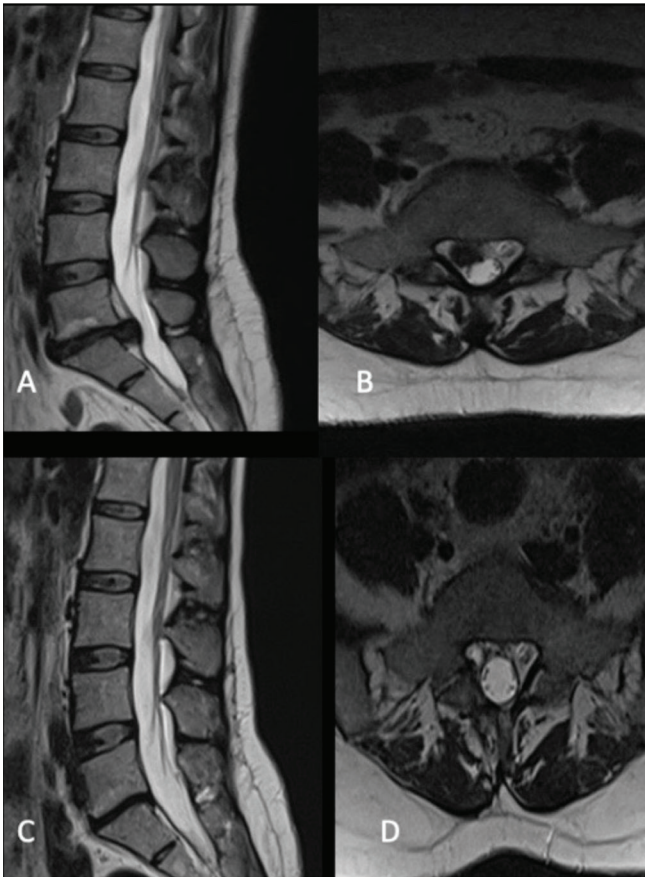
Pre-op and post-op T2 sequence magnetic resonance images
